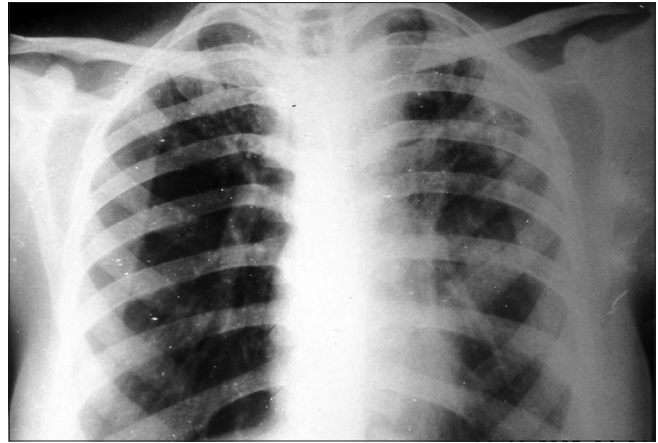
Chest x-ray shows bronchovascular markings are accentuated, with left upper zone Pulmonary Koch's
